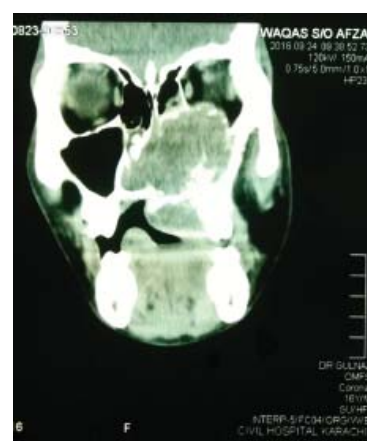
CT scan shows heterogeneous mass with bony erosion involving both nasal cavity, left maxillary sinus and left orbit
